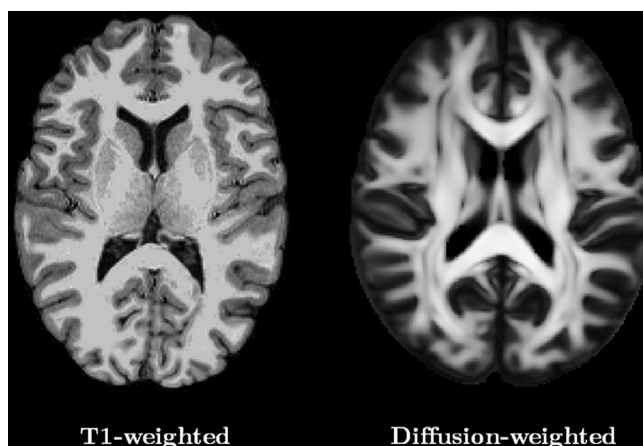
Visualization of common MRI sequences.
